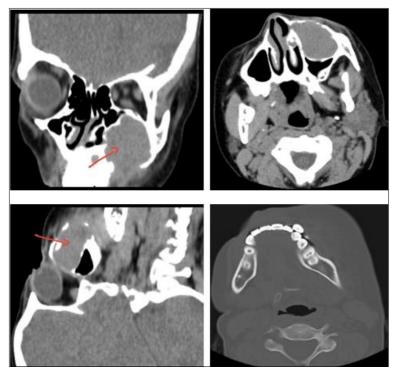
CT Para nasal sinuses
